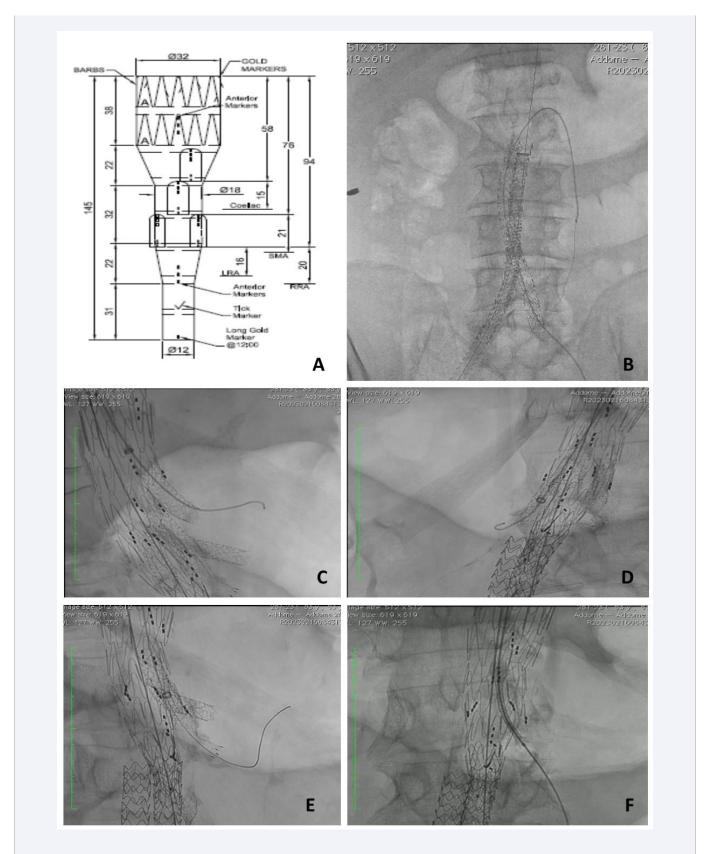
(A) Customized endograft shape and size with four directional branches for superior mesenteric artery (SMA) and celiac trunk (CT) and two internal branches for renal arteries. LRA, left renal artery; RRA, right renal artery; (B, C, D, E, F) Intraoperative angiographic image. Image showing the result after its introduction into the right leg of Nellix.
